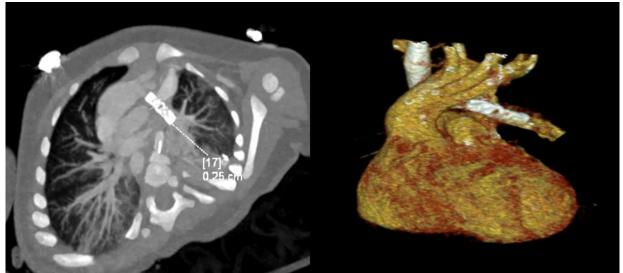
angio-CT showing stent position from the origin of LSA to the Left pulmonary artery.
